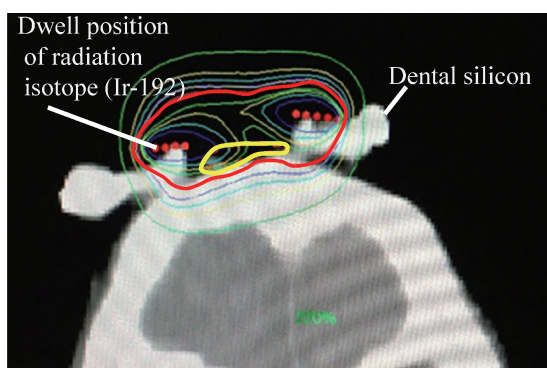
Dose distribution curve on coronal view of planning computed tomography. We achieved good coverage of the clinical target volume (yellow line) by the planning-aim dose (6 Gy in fraction; red line).
